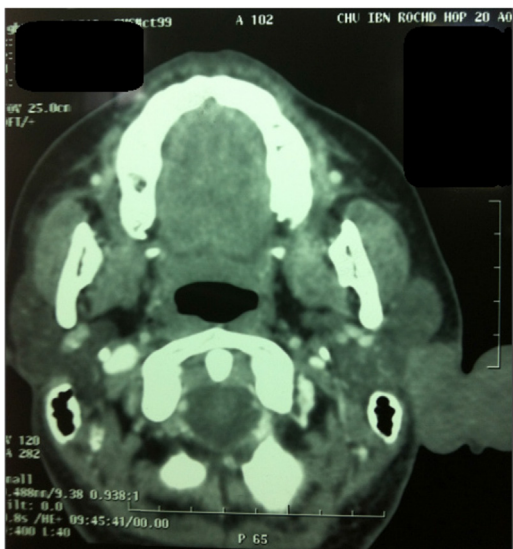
CT scan showing invasion of the soft tissues of the left auricle.
